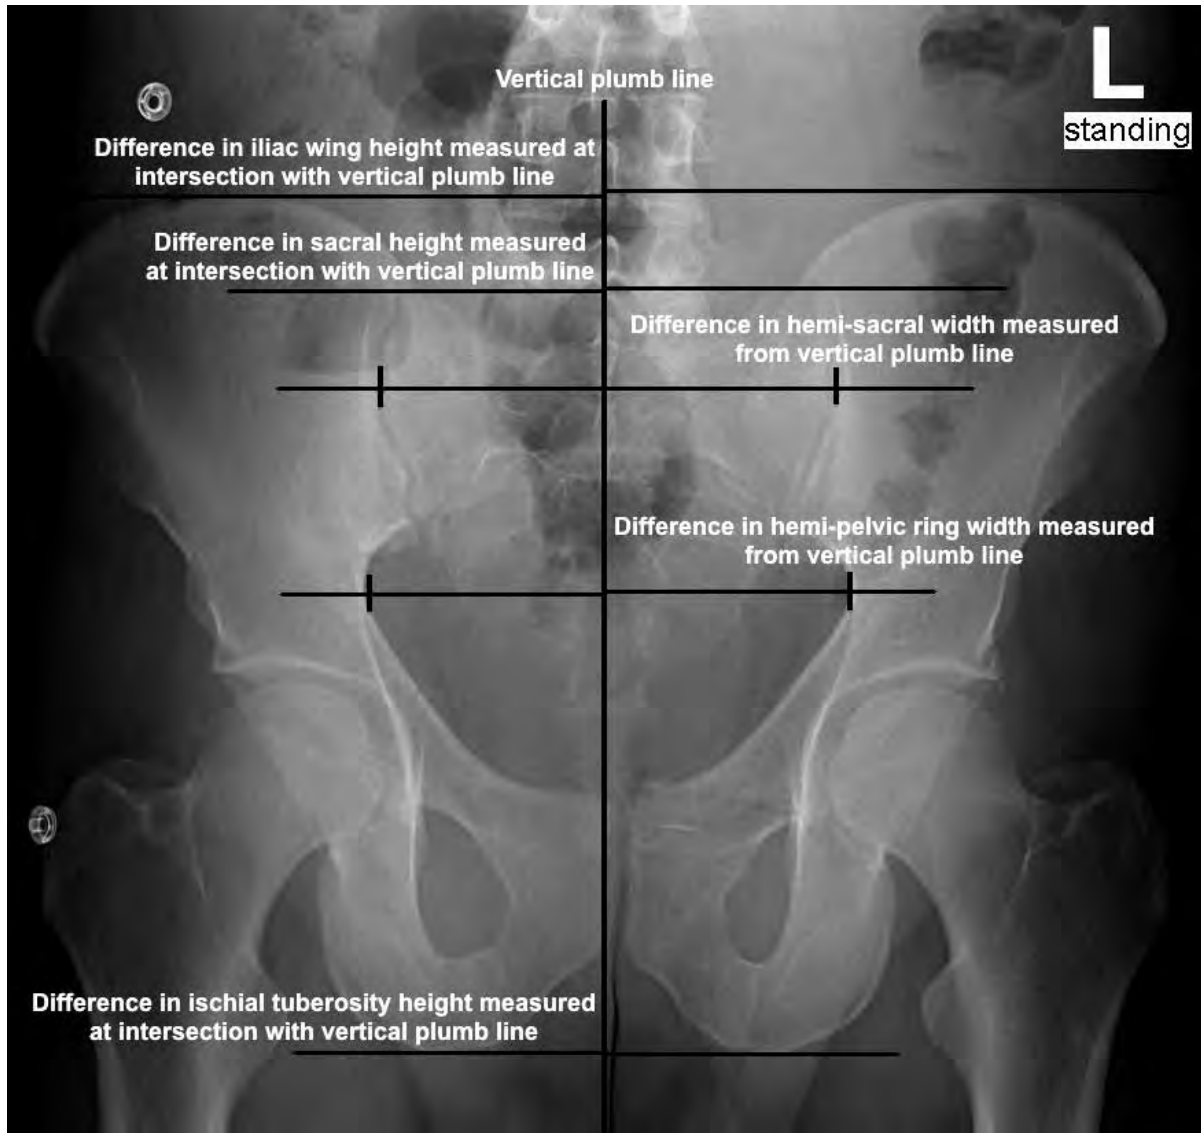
AP pelvis radiograph demonstrating measurement technique. A vertical plumb line was drawn through the midline of the spine and sacrum with perpendicular lines at the level of the iliac wing height, sacral height, ischial tuberosity height, sacral width, and pelvic ring width. The difference in height was recorded.
